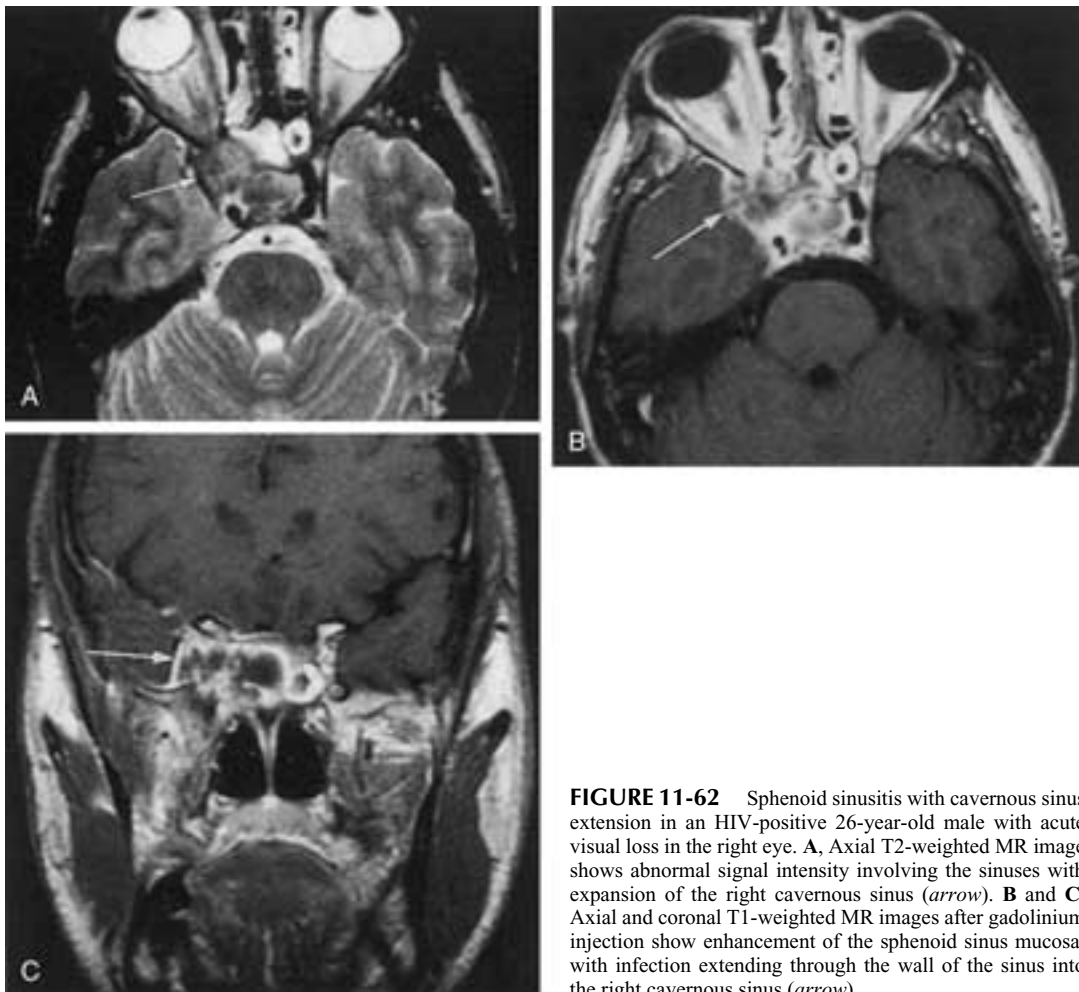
Sphenoid sinusitis with cavernous sinus extension in an HIV-positive 26-year-old male with acute visual loss in the right eye. A, Axial T2-weighted MR image shows abnormal signal intensity involving the sinuses with expansion of the right cavernous sinus (*arrow*). B and C, Axial and coronal T1-weighted MR images after gadolinium injection show enhancement of the sphenoid sinus mucosa, with infection extending through the wall of the sinus into the right cavernous sinus (*arrow*).
